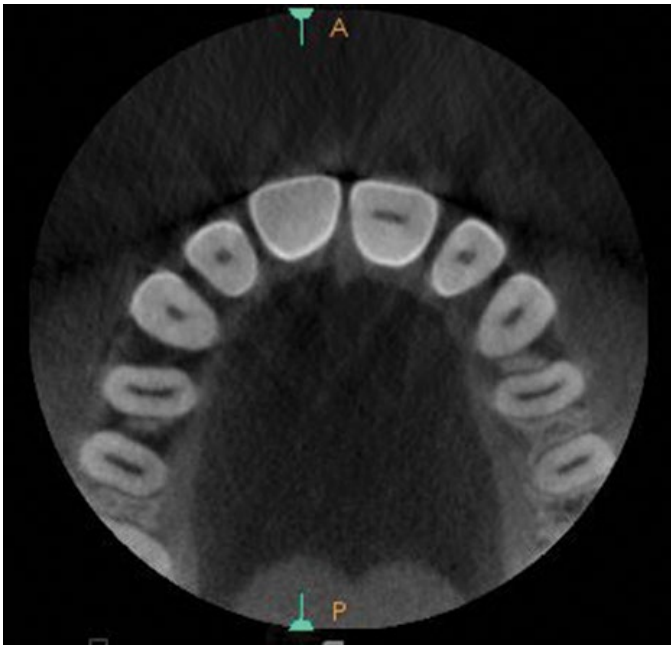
(F) The 3D CBCT image demonstrates complete calcification of #8 pulp chamber.
